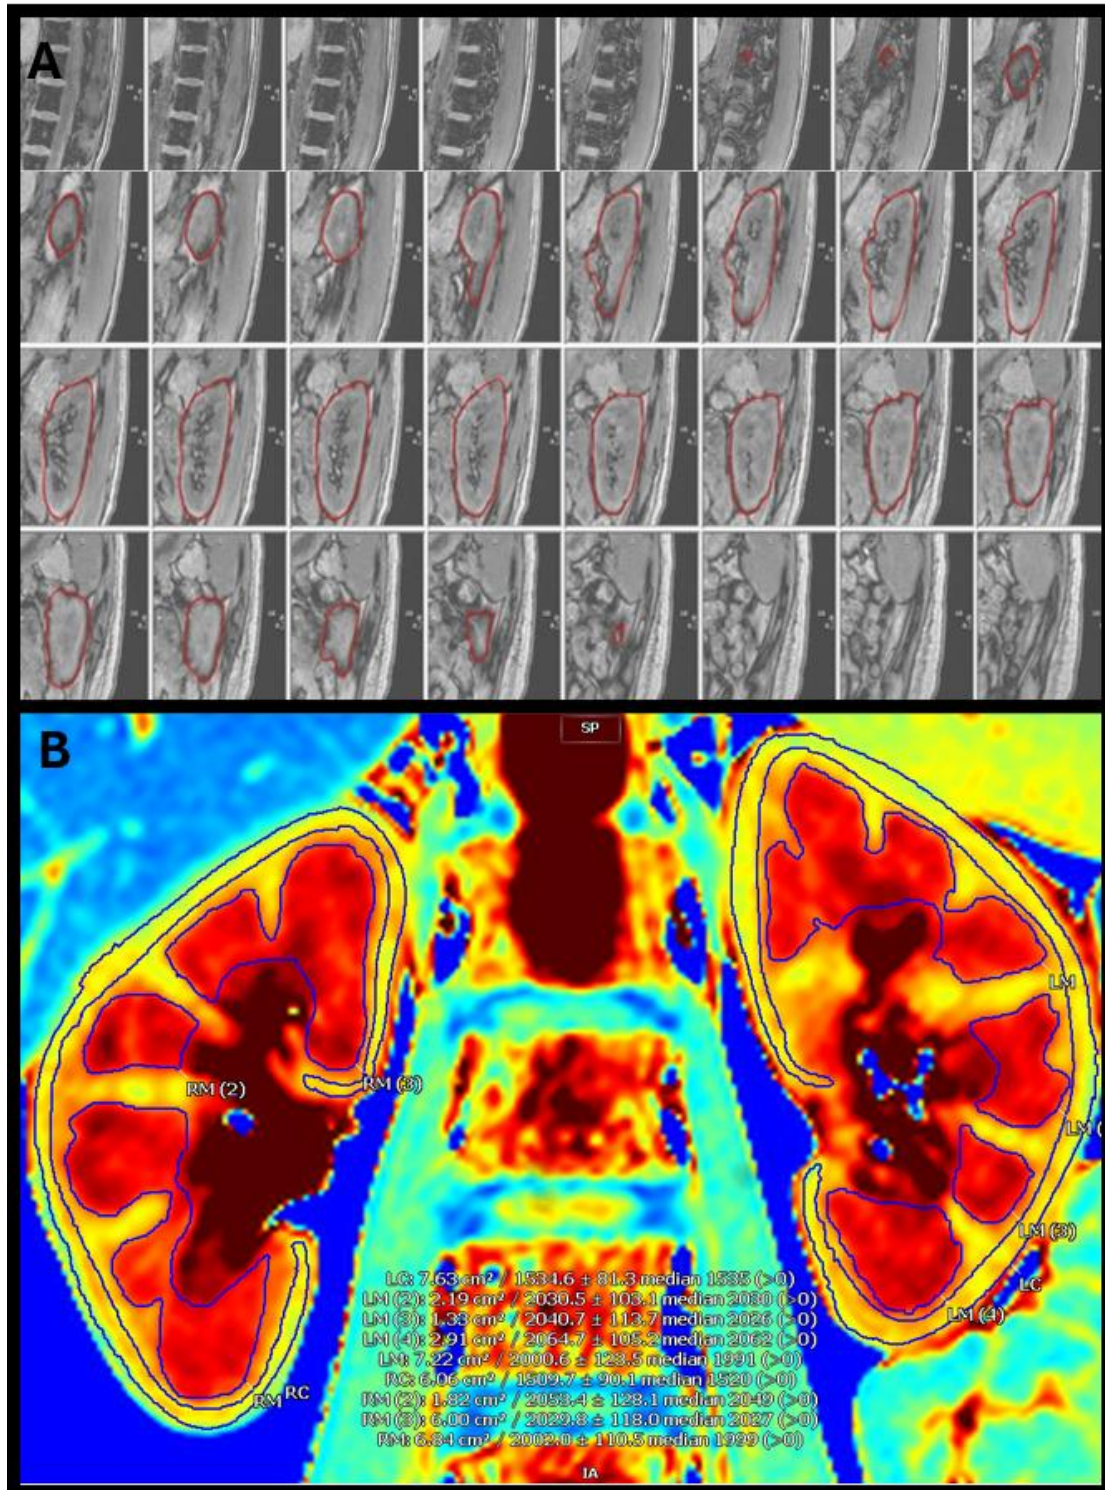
Analysis of renal structure using magnetic resonance imaging in CVI42.
